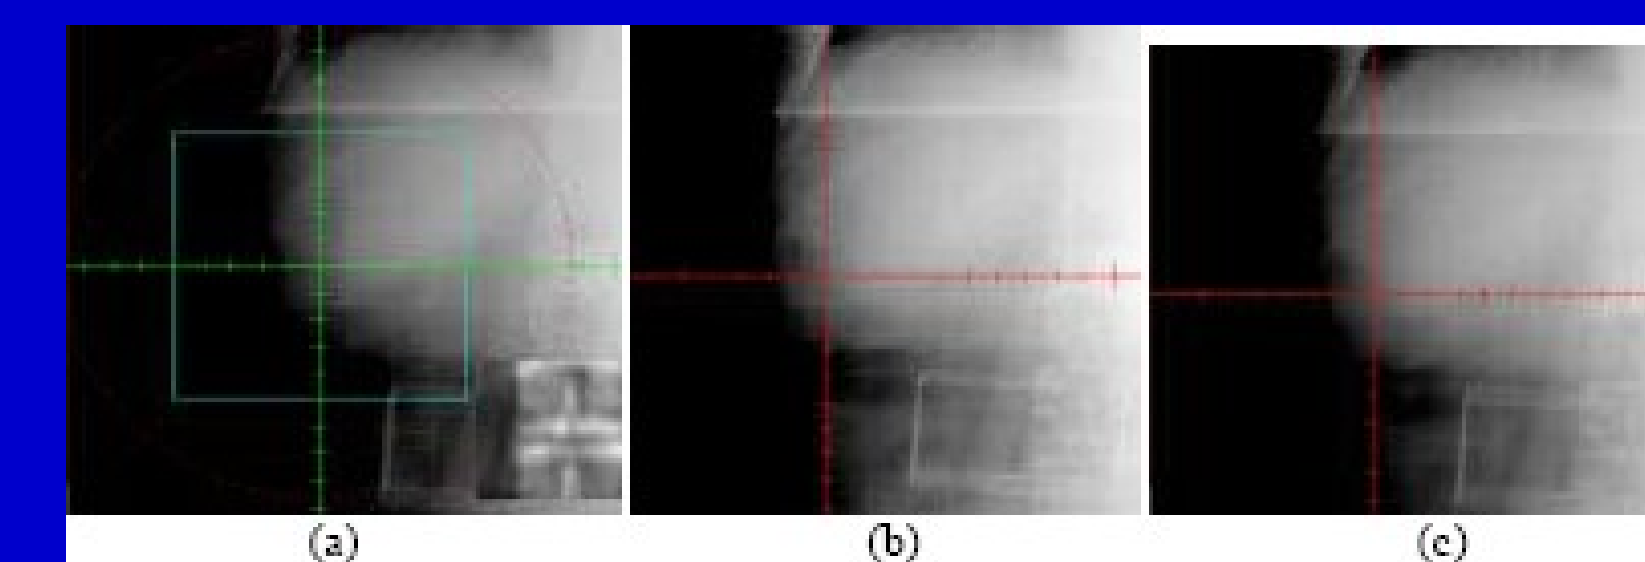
kV radiographs for the liver case taken before correction (a), after correction but before treatment (b), and after treatment. Implanted markers are used to document the deviations (c).
